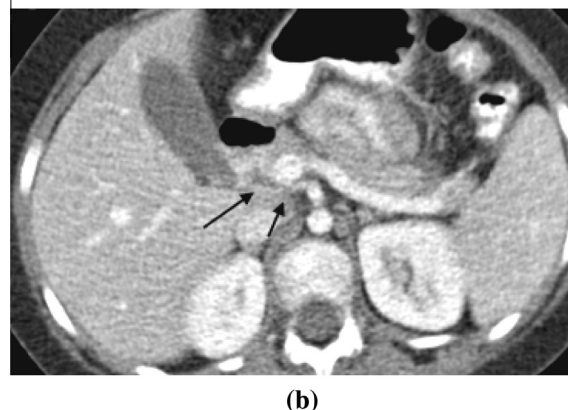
Post contrast CT of the abdomen coronal reconstruction and axial images (a and b) showing aberrant right hepatic artery arising from the superior mesenteric artery (black arrows).
